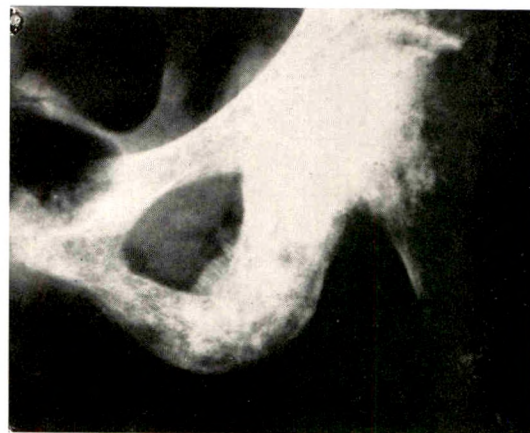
Anteroposterior roentgenogram of left hip—a contact reproduction.
